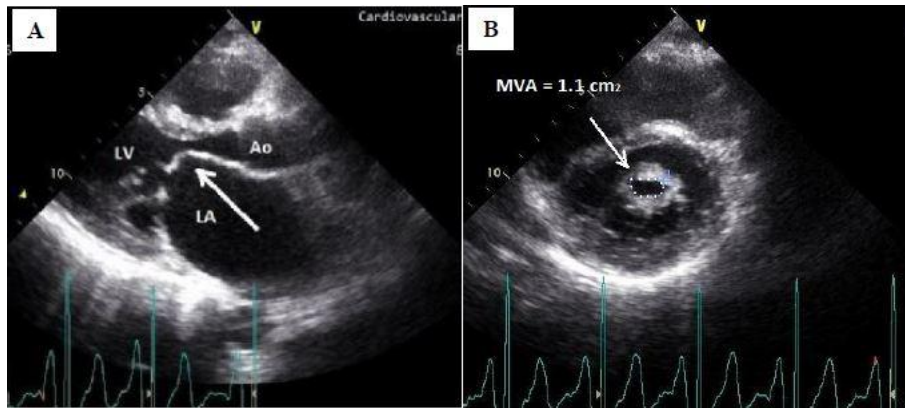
2D echocardiography in a patient with rheumatic mitral valve stenosis
